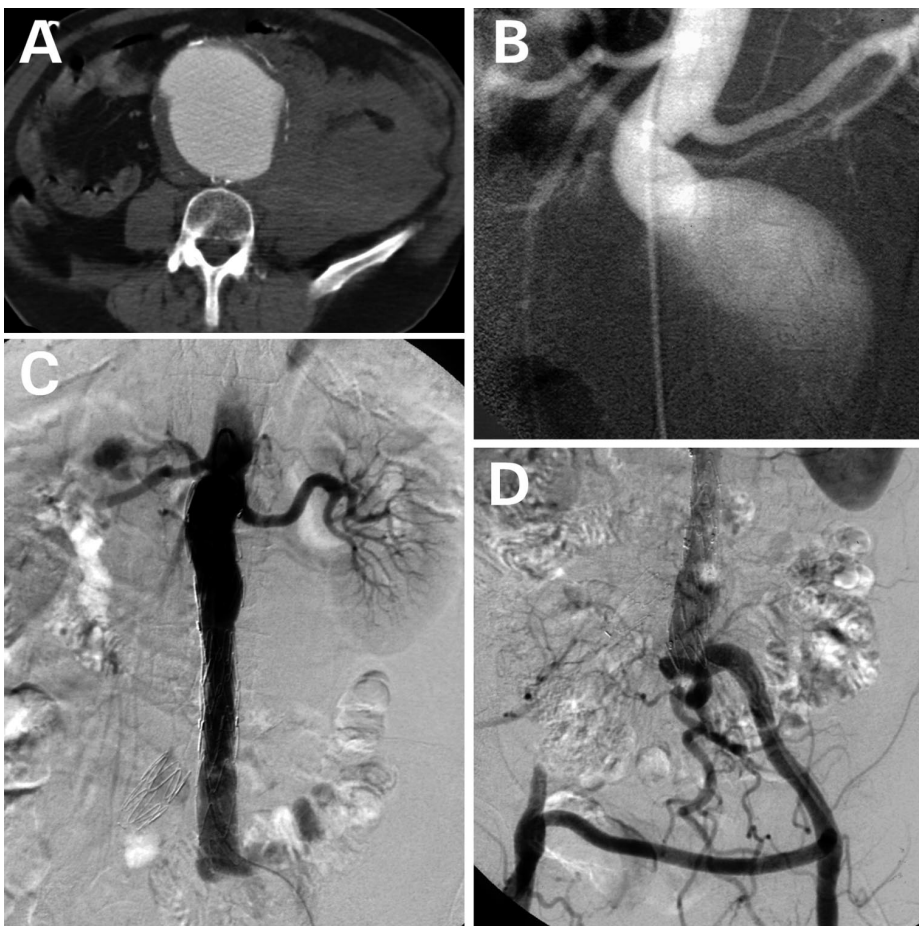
(A) Preoperative CT scan demonstrates periaortic extravasation of blood. (B) Intraoperative angiogram. (C) Completion angiogram showing the aortomonoiliac endograft to the left iliac artery and (D) the "occluder" in the right common iliac artery.
